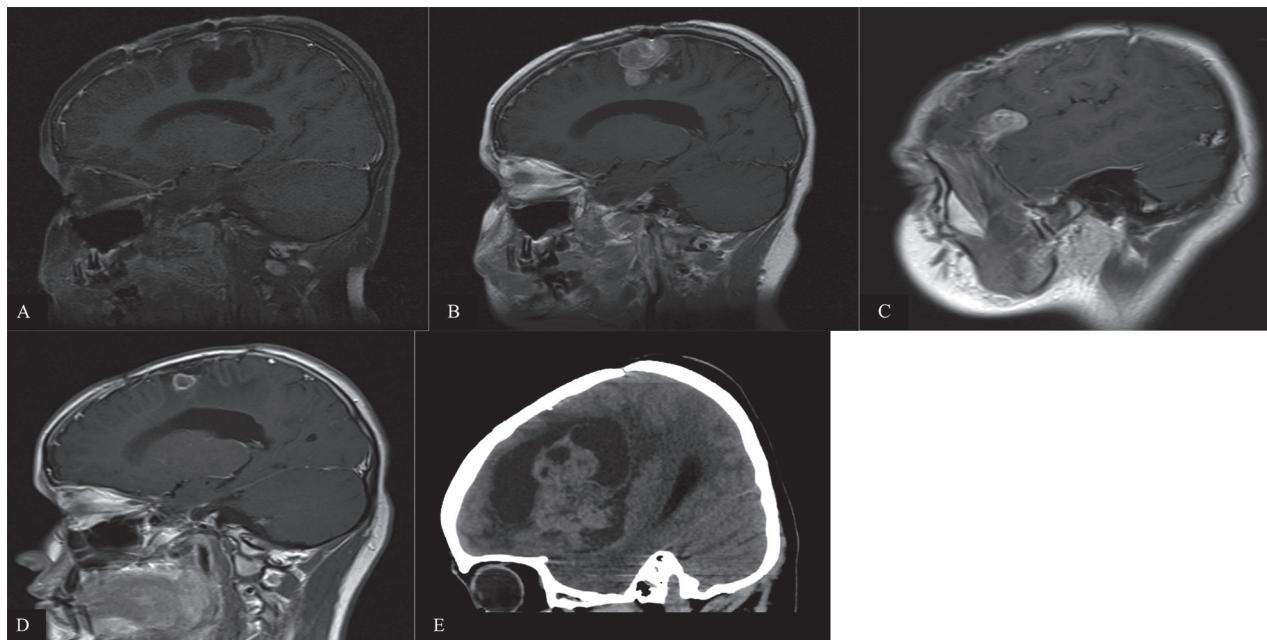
A: Parasagittal T1W MR image with fat saturation and postcontrast administration demonstrating the first postsurgical cavity in the left frontal area. B: A few months later, MR images obtained in sagittal plane of T1WI with contrast show the recurrent enhancing nodules in the surgical cavity. D: Follow up MRI 1 year after the second resection shows the residual ring-enhancing lesion at the surgical cavity of the left frontal lobe. C: A new intra/extracystic enhancing mass at the left perisylvian region is identified. E: Extensively enlarged left perisylvian mass with solid-cystic components seen on parasagittal post enhanced CT scan reformatted image.
